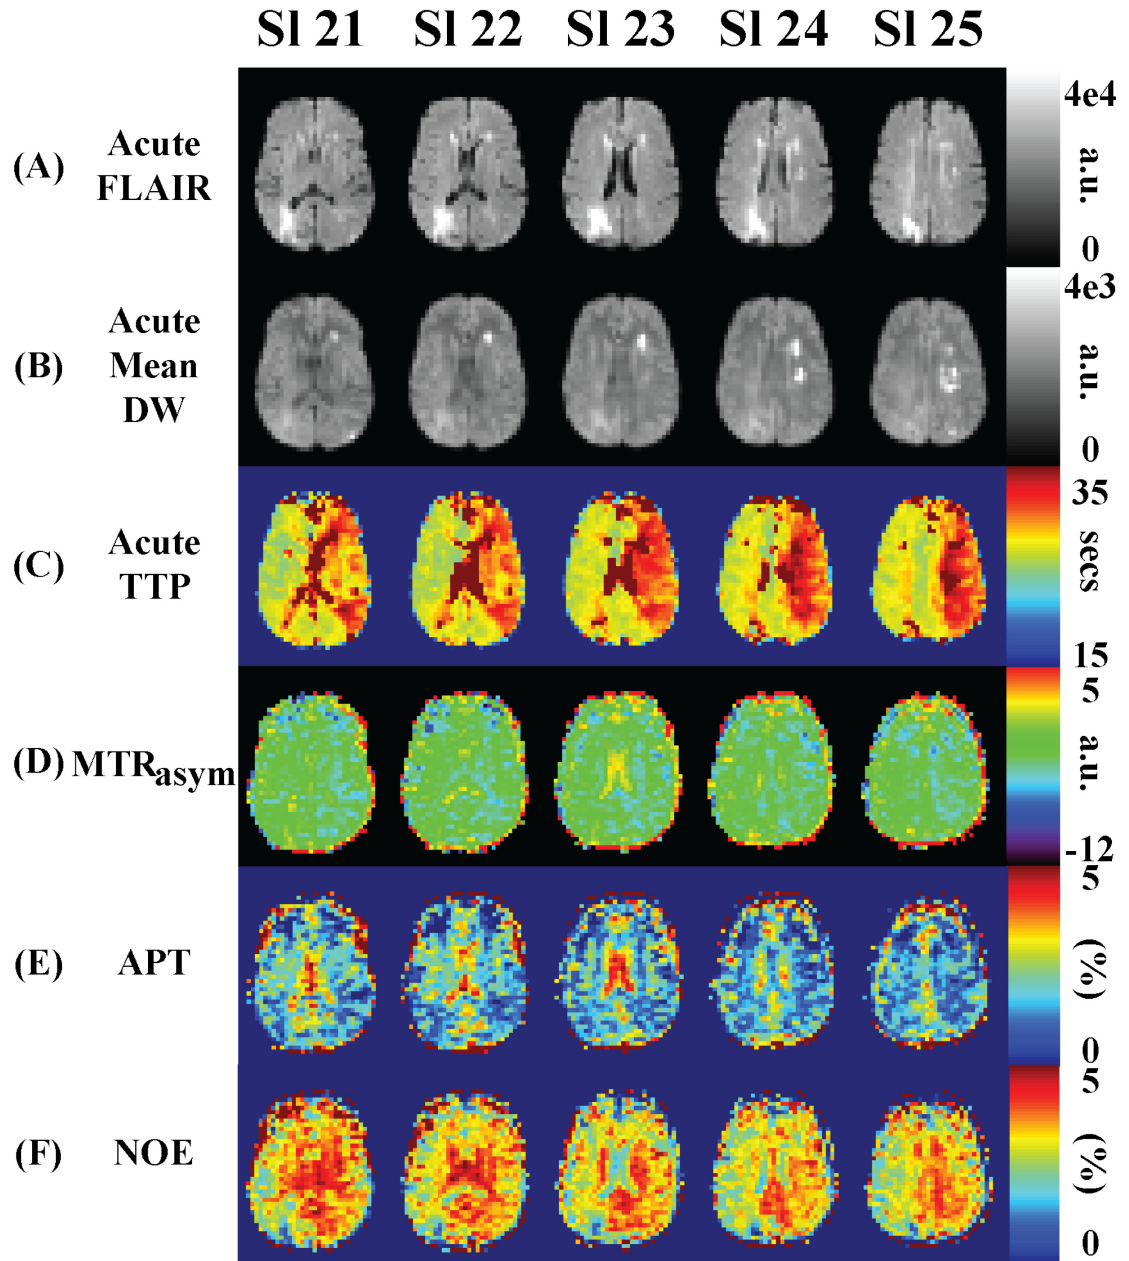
Processed data for carotid artery stenosis patient (Slices 21-25) (displayed in radiologic convention). (A) Acute FLAIR scan (B) Acute Mean Diffusion Weighted scan (C) Acute Time to Peak scan (D) MTR<sub>asymmetry</sub>(3.5 ppm) (pH-weighted) (E) APT (F) NOE
